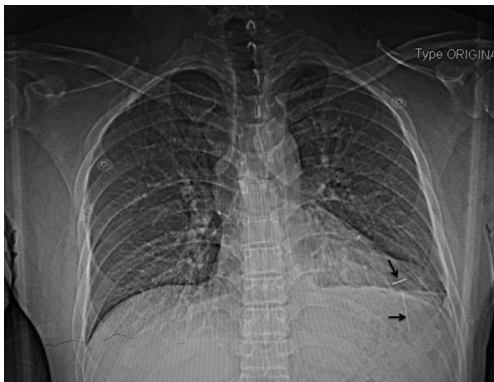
Chest X-ray revealed two needles (arrows) in the chest.
